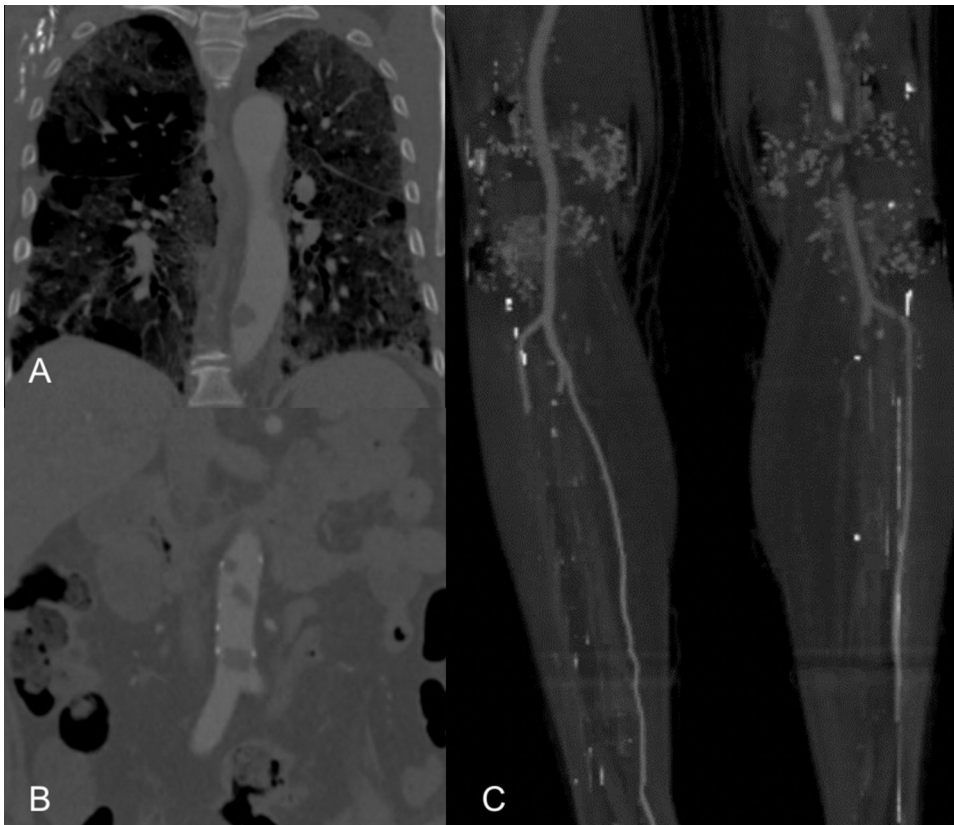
(A and B) Computed tomography angiography (CTA) demonstrating acute multifocal thrombus formation in the descending thoracic and abdominal aorta. (C) CTA demonstrating segmental occlusion of the left popliteal artery, occlusion of the tibioperoneal trunk and posterior tibial artery, as well as partial occlusion of the peroneal artery.
